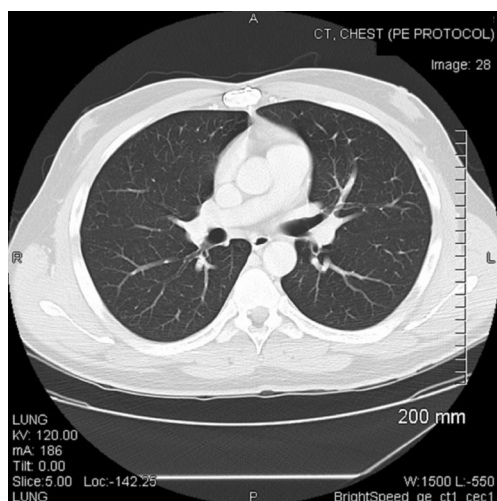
Chest computerized tomography (CT) after surgery scan showing multiple emboli in the right lower lobe segmental and subsegmental pulmonary arterial branches, as well as peripheral airspace disease in the right lower lobe suggestive of pulmonary infarction
